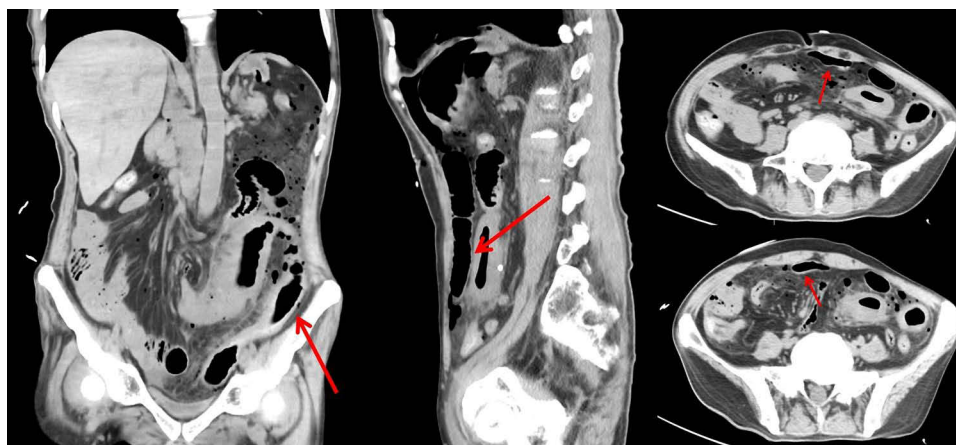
Emergency abdominal CT images. The images reveal gastrointestinal perforation (indicated by arrows), irregular morphology of the small bowel, and pelvic effusion localized in the right lower abdomen on May 6, 2023.
